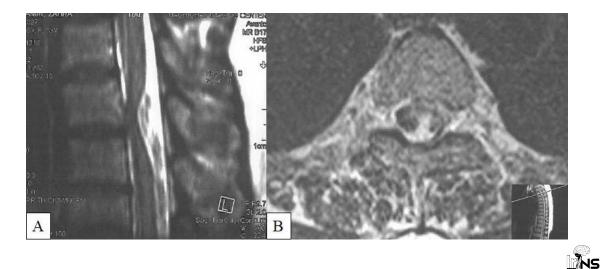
Pre-operative sagittal (A) and axial (B) magnetic resonance imaging (MRI) T2W images showing clear abnormal anterior displacement of the spinal cord at the T3/T4 level, a C-shaped kink, and atrophy
